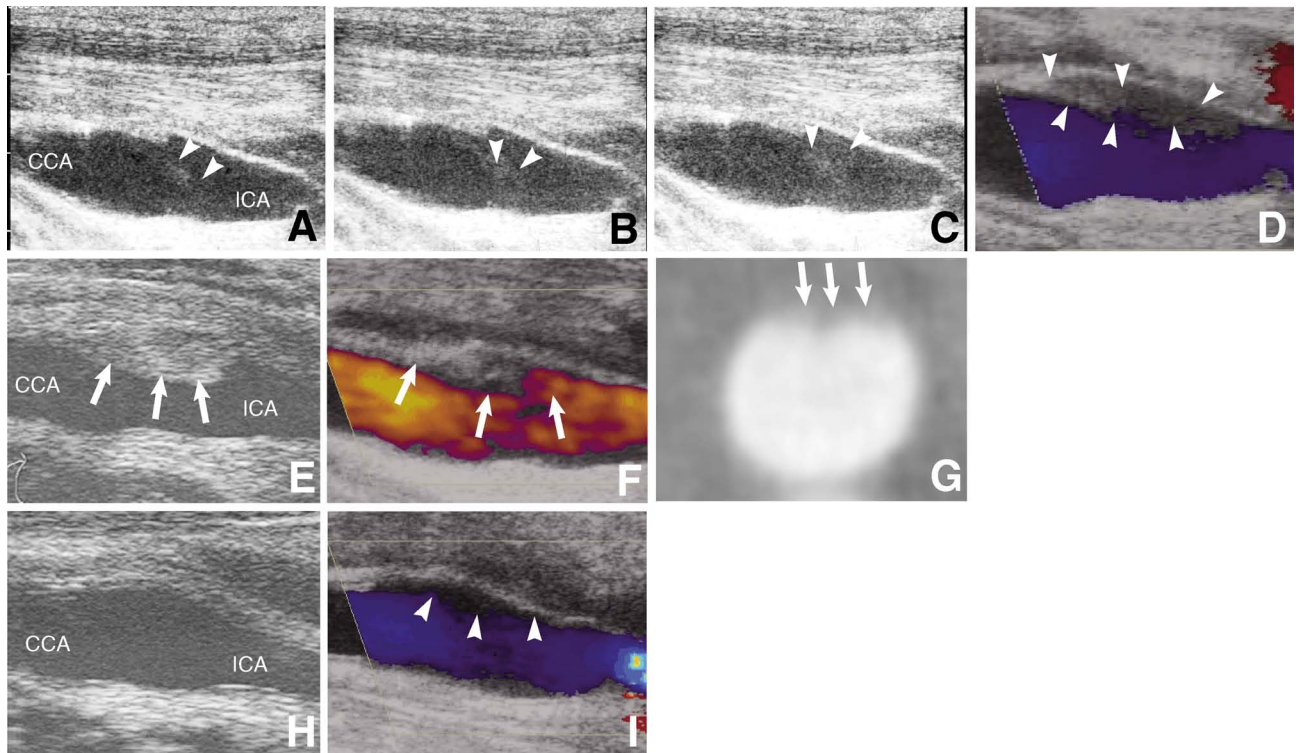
Postoperative course of a 64-year-old man (Case 6). A–C: Ultrasonography scans taken 1 day after carotid endarterectomy (CEA) revealing slight high signal swirling (arrowheads) at the ventral portion of the operated carotid artery suggesting spontaneous echo contrast. D: Color Doppler sonography scan showing the main stream of the carotid artery located on the opposite medio-caudal side, and marked decrease of the blood flow (arrowheads) at the ventro-lateral portion of the operated carotid artery. E: Ultrasonography scan taken 6 days after CEA showing marked de novo thrombosis formation (arrows) at the ventral side of the carotid artery where slow blood flow was previously seen. F: Power Doppler sonography scan showing absence of the blood flow (arrows) at the thrombosis. G: Three-dimensional computed tomography angiogram taken 6 days after CEA showing absence of the blood flow (arrows) at the ventral portion of the operated carotid artery suggesting acute thrombus. H, I: Ultrasonography scan taken 13 days after CEA showing the carotid thrombosis had completely disappeared with anticoagulant therapy (H), but color Doppler sonography scan showing local blood stasis was still present at the ventro-lateral portion of the carotid artery (I, arrowheads). CCA: common carotid artery, ICA: internal carotid artery.
